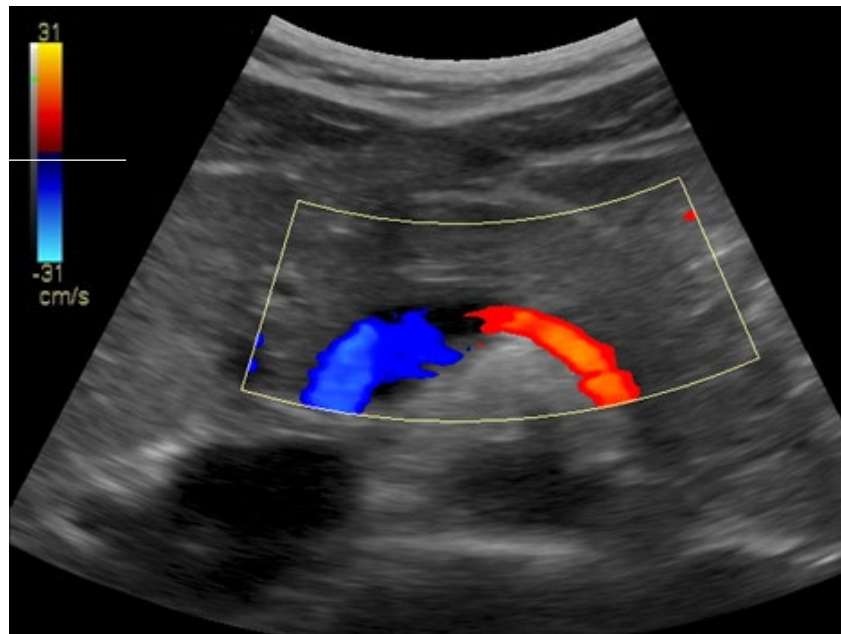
Splenic vein with colour Doppler overlay. The flow velocity (in cm/s) and flow direction are indicated in the scale on the left side of the ultrasound image.
